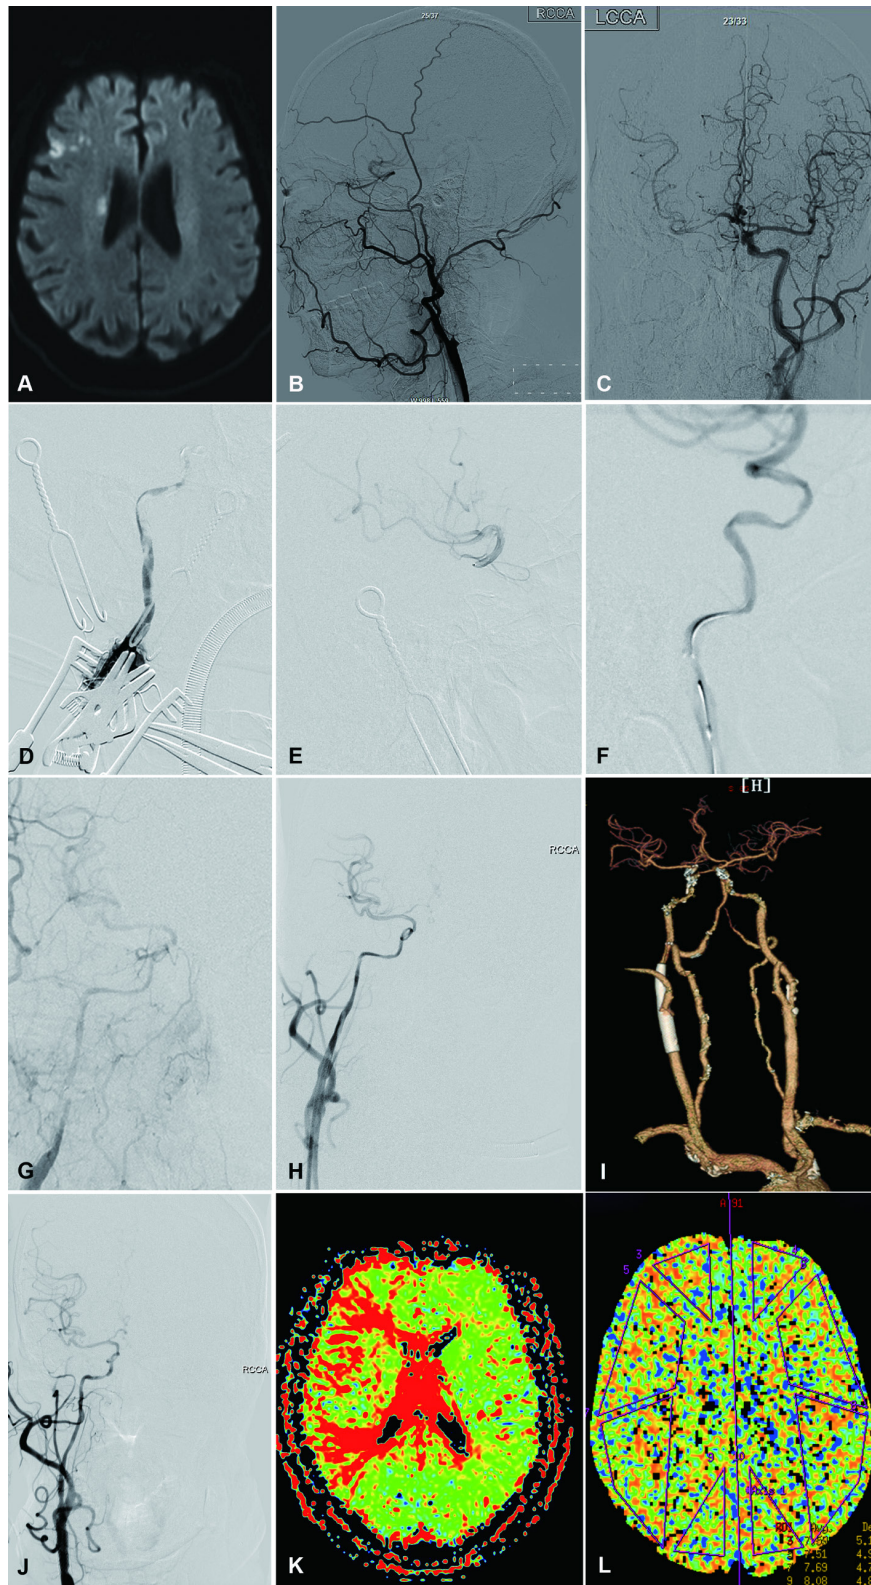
Case example. Case 11 with paroxysmal left-sided limb weakness and dysphasia underwent hybrid procedures for a symptomatic chronic internal carotid artery occlusion (ICAO). Diffusion-weighted imaging showed new infarcts in the right hemisphere (A). Preoperative angiography confirmed right ICAO, with ophthalmic artery collateral (B) and anterior communicating artery collateral (C). Angiography through the carotid sheath after carotid endarterectomy showed C4 occlusion with C1 and C2 dissection. After the microcatheter was placed in C6 (E), three Enterprise stents (two 4.5×37 mm and one 4.5×28 mm) were implanted in tandem from C6 to distal C1 across the lesion with Thrombolysis in Myocardial Infarction 3 recanalization (F). Angiography via a femoral approach after closing the internal carotid artery (ICA) arteriotomy showed a C1 dissection (G), which was reconstructed by implantation of a 9×50 mm Wallstent (H). The ICA remained patent on CT angiography at 6 days (I) and angiography at 11 months after the procedure (J). Mean transit time on preoperative perfusion-weighted imaging was prolonged in the right hemisphere (K) and normalized on postoperative CT perfusion (L).
